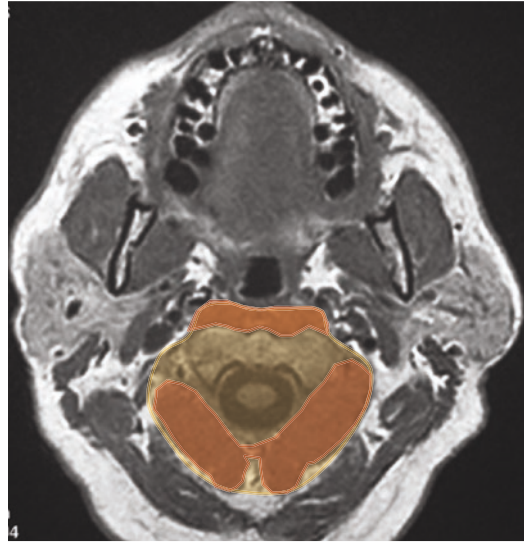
Axial T1W MRI demonstrating the position of the perivertebral space (yellow) with pre- and paravertebral muscles highlighted in orange
